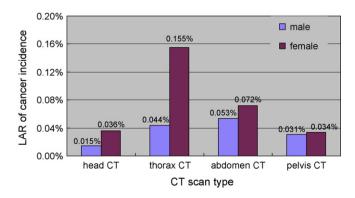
Lifetime attributable risk of cancer incidence in 5-year-old children induced by CT scan. Note—estimated excess cancer incidence risks attributable to radiation from CT scan on children. Four CT scan types with different scanning parameters were studied. The risks to 5-year-old boys and girls are shown.
